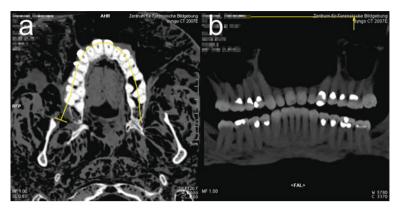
Dental reconstruction for comparison with ante-mortem images (Leonardo). (a) Curve along which the orthopantomogram is calculated. (b) MIP orthopantomogram along the path in a
